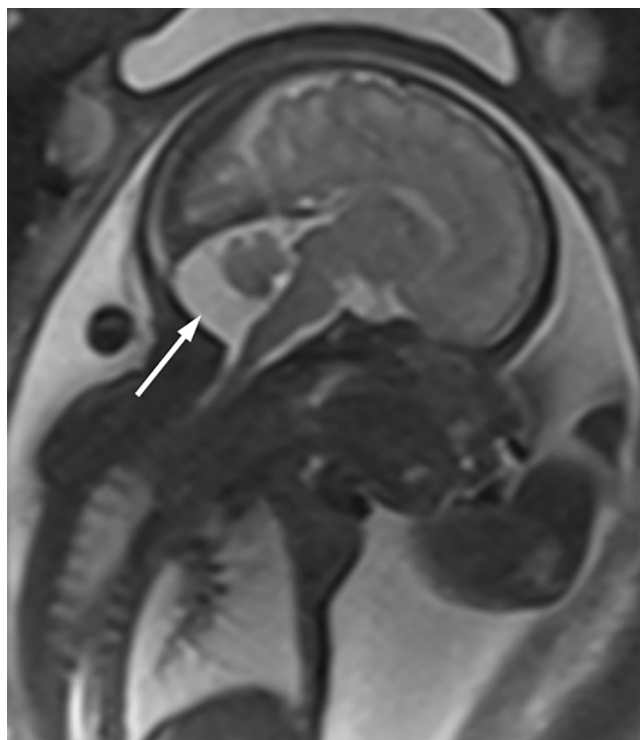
Mid-sagittal half-Fourier acquisition single-shot turbo spin-echo (HASTE) image from 3T magnetic resonance imaging of the fetal brain at 33 weeks gestation. The enlarged cerebrospinal fluid space (arrow) posterior and inferior to a normal cerebellar vermis in the absence of hydrocephalus suggests mega cisterna magna
